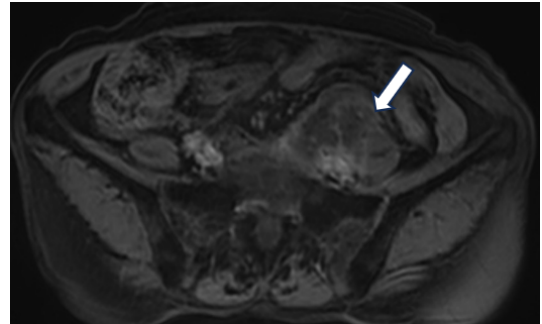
MRI enhanced scan image.
